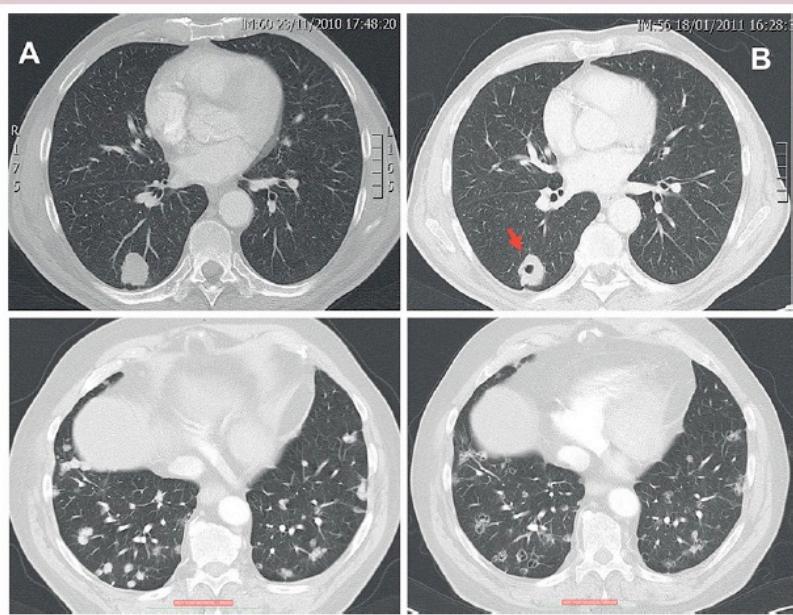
Baseline (A) and week 8 (B) CT displaying the onset of cavitation at week 8 in two patients treated with regorafenib. Upper: the arrow highlights single tumour metastases with cavitation. Lower: cavitation in multiple lung metastases.
